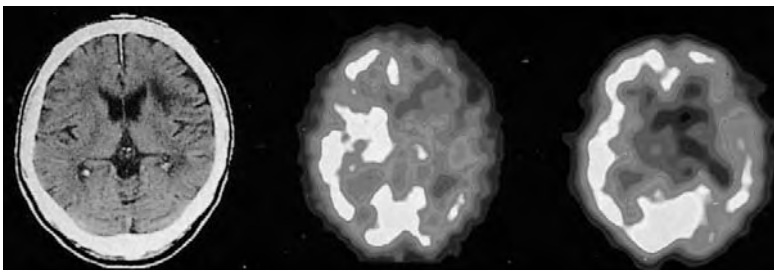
^{123}I -iomazenil SPECT study (*right*) in a 61-year-old patient with purely subcortical infarction 46 days after onset. CT scan (*left*) shows hypodensity in the frontal deep white matter with no involvement of the cortical area. Blood flow measured with ^{123}I -IMP (*center*) was reduced in the frontal and temporal cortices, basal ganglia, and thalamus ^{123}I -iomazenil image (*right*) demonstrated reduced uptake in the Broca area and milder reduction in the frontal and temporal lobes that were normal on the CT images. The patient presented with global aphasia
